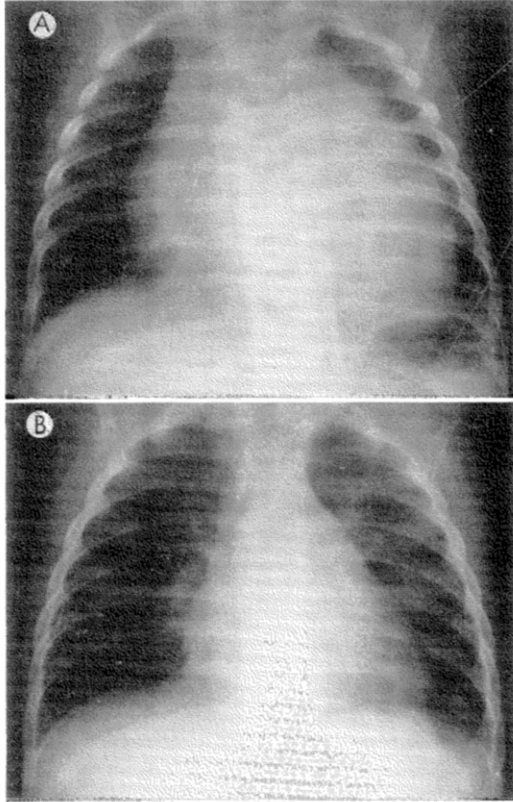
A*, marked cardiomegaly on day of admission. *B*, roentgenogram 6 weeks later. Heart size has returned to normal.
